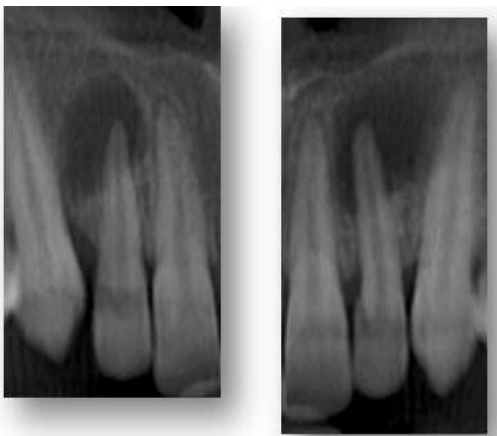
CBCT images of 12 &22
